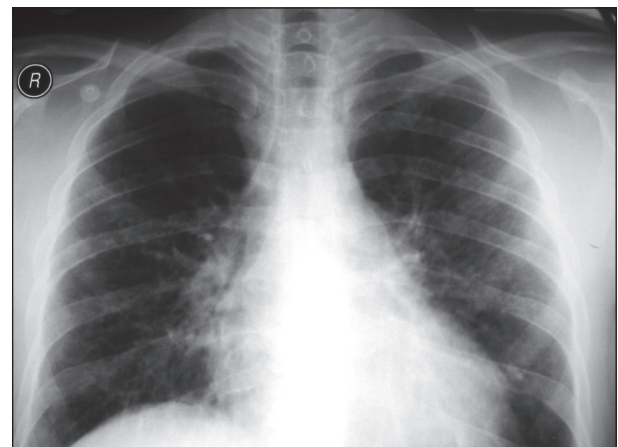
Chest radiograph of Varicella pneumonia showing linear and focal pulmonary opacities
